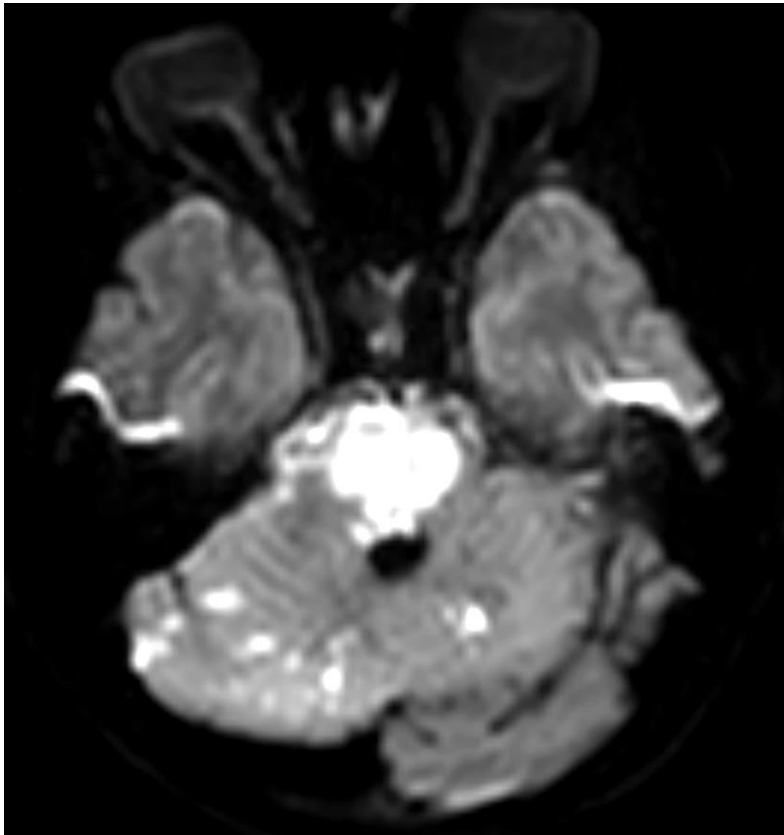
MRI showing diffusion restricting lesions on the brainstem
